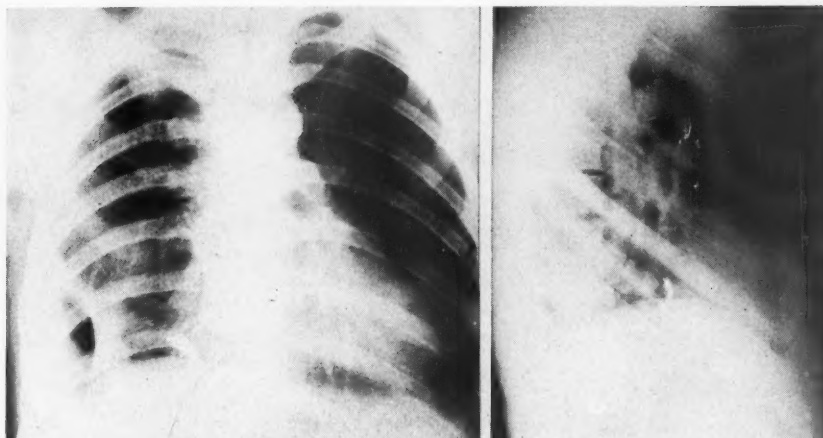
Roentgenogram showing shrapnel fragment in right lower midchest which has not been removed because of absence of symptoms. The empyema is cured.
